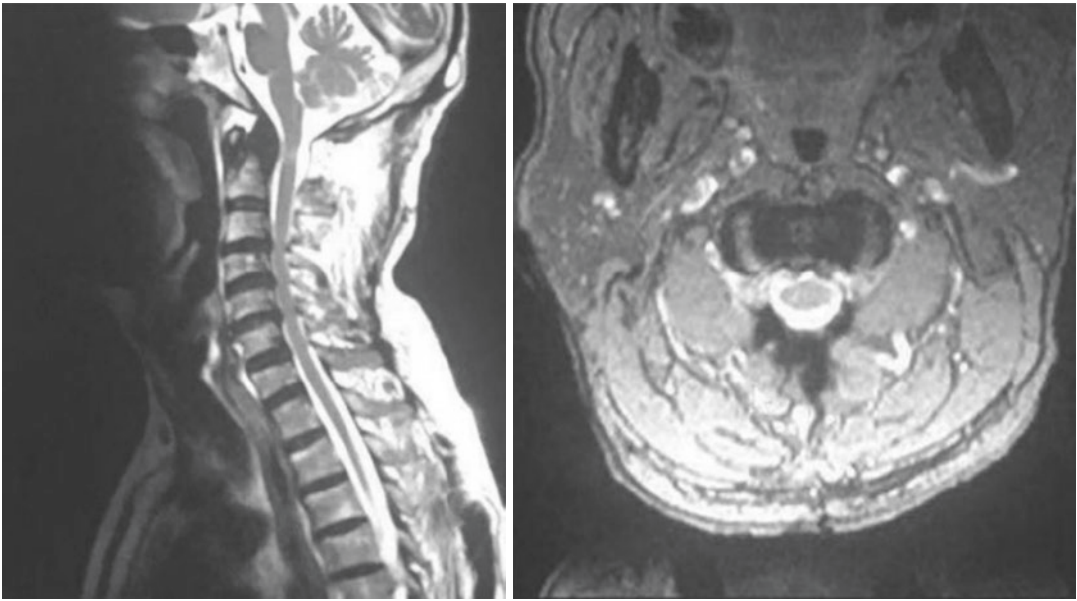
Postoperative MRI
